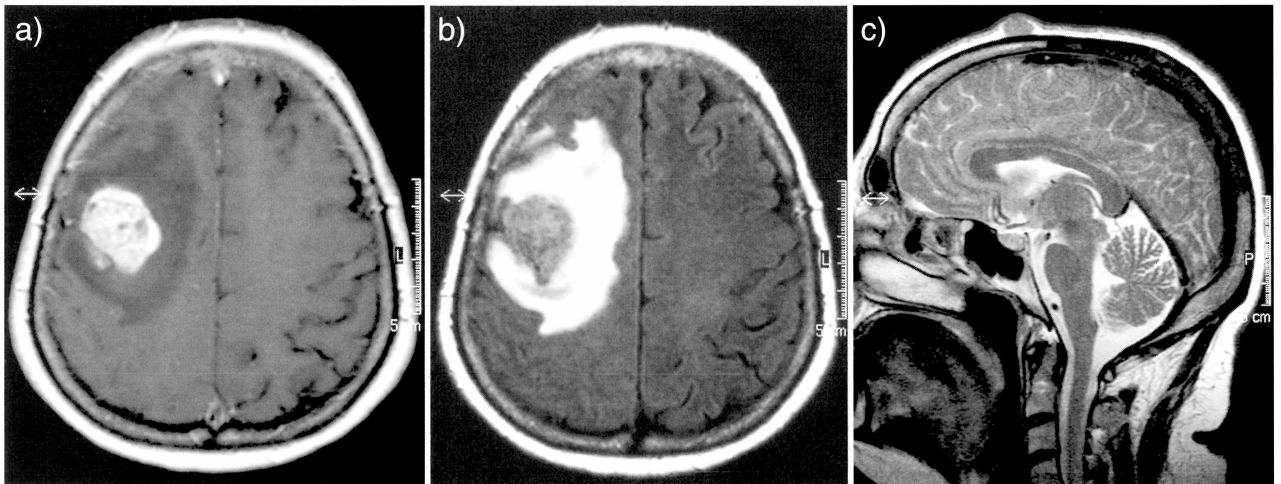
Magnetic resonance imaging with axial T1-weighted post-contrast sequences a) and flair sequences b) show a large metastasis in the right frontal lobe with surrounding edema. On the sagittal T2-weighted sequence c) an additional subcutaneous metastasis is demonstrated.
